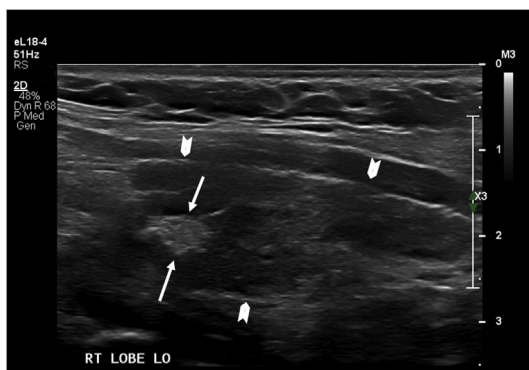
A 13-year-old girl with focal echogenic nodule (white arrows) on gray-scale ultrasound; the “white knight” pattern is benign in the setting of Hashimoto disease (right lobe longitudinal plane). Arrowheads show the thyroid border.
